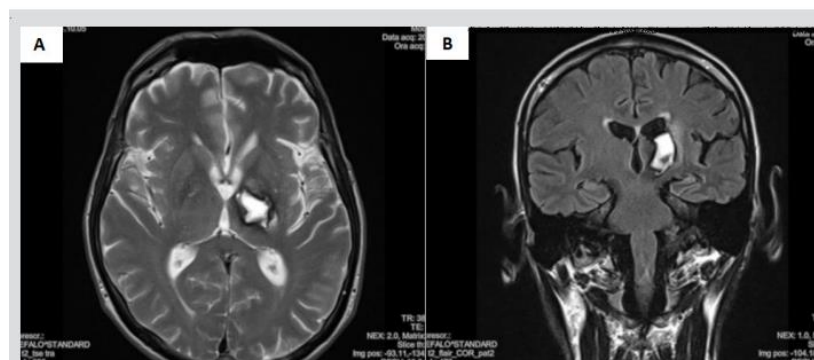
Cerebral magnetic resonance imaging performed in the acute phase. T2-weighted axial (A) and T2-flair sagittal (B) slices disclosed a hyperintense area in the left thalamus.
